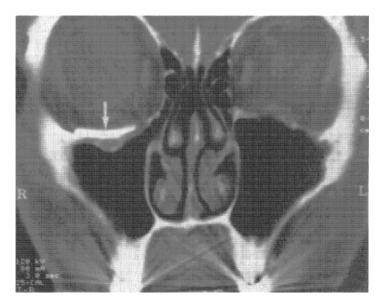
(b). CT scan of the same patient taken four months after correction of the fracture using a curved bioactive glass (S53P4) implant (arrow). (Courtesy of Dr. Kalle Aitasalo, Department of Otolaryngology, University Central Hospital of Turku, Turku, Finland.)
